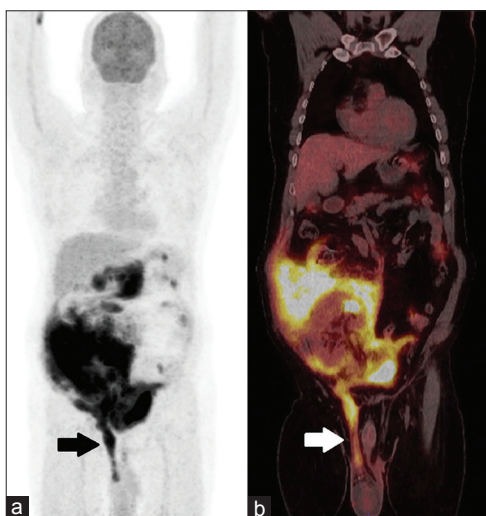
Baseline (a) 18-fluorodeoxyglucose positron emission tomography-computed tomography maximum intensity projection reconstruction of computed tomography attenuation corrected image and (b) 18-fluorodeoxyglucose positron emission tomography-computed tomography (fused) coronal reconstruction image revealing intensely fluorodeoxyglucose-avid primary lesion encasing the transplanted kidney, invading the adjacent ascending colon, caecum, and distal part of ileum. The lesion is also extending in right inguinal canal (arrow)
